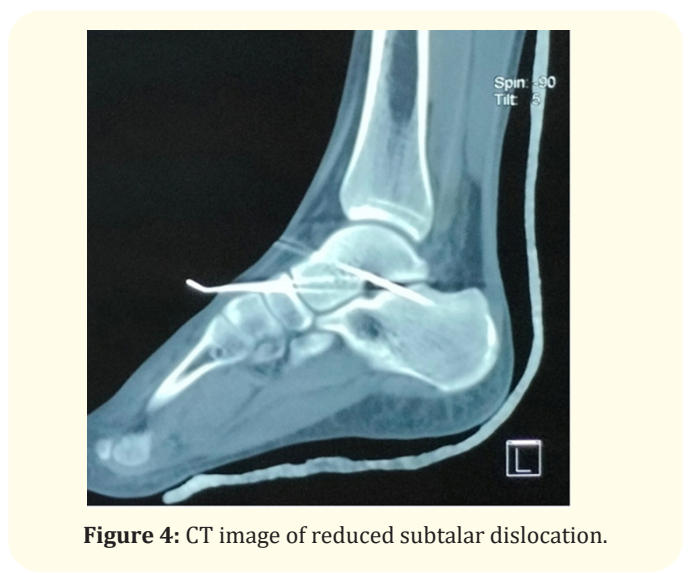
CT image of reduced subtalar dislocation.
